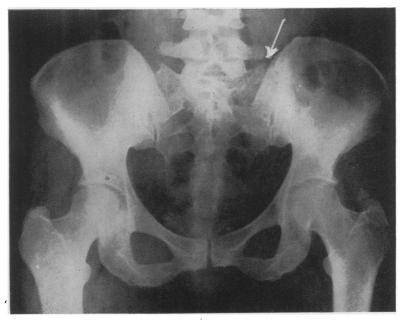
Case 4: This roentgenogram was taken three months after the one shown in the preceding figure. In the interim the patient had received 2,150 milligrams of testosterone propionate. The increased density in the involved ala is well-defined.
